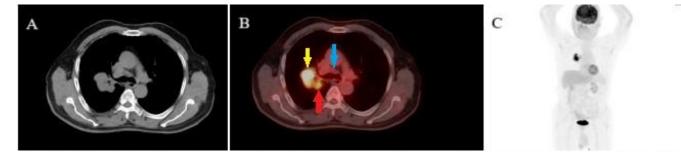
Computed tomography image (A), fusion PET/CT image (B)-primary malignant mass (yellow arrow), metastatic hilar lymph node (red arrow), non-metastatic precarinal lymph node (blue arrow), and MIP image (C) in a case of non-small cell lung cancer.
